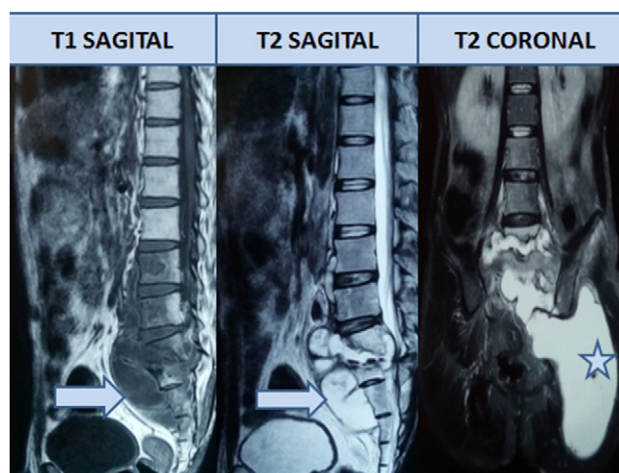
MRI images showing lesions on the LS region that was hypo-intense lesion on T1, hyper-intense lesion on T2 and also collection in the pre-sacral and left pelvic region.
